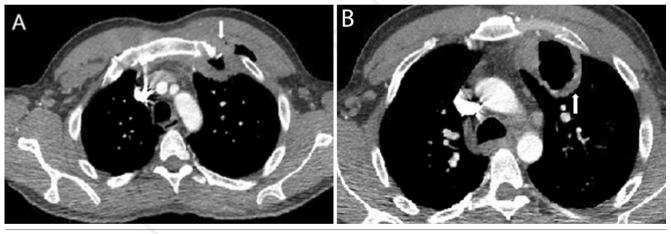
A) Axial cross-sectional images of Computed Tomography of chest, demonstrating air (arrow) tracking across the pectoralis muscle into the subcutaneous tissue planes. B) Axial cross section of CT chest demonstrating left upper lobe cavity (arrow).
